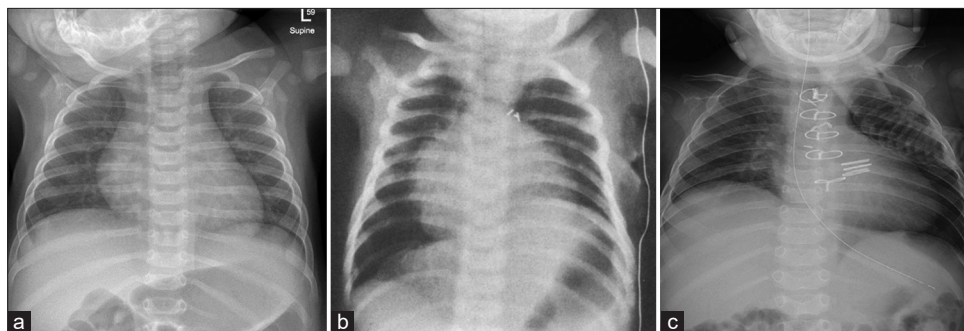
Chest radiograph showing: (a) Normal diaphragm appearance, (b and c) elevation of left and right hemi-diaphragm; respectively, following phrenic nerve paralysis in patients with post-cardiac surgery
